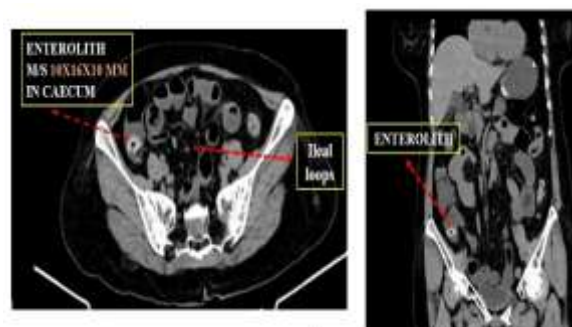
CT Abdomen after 6 days of Dissolution therapy - Axial and Coronal views - showing reduction in size of enterolith to 10x16x10 mm and migration to caecum.
